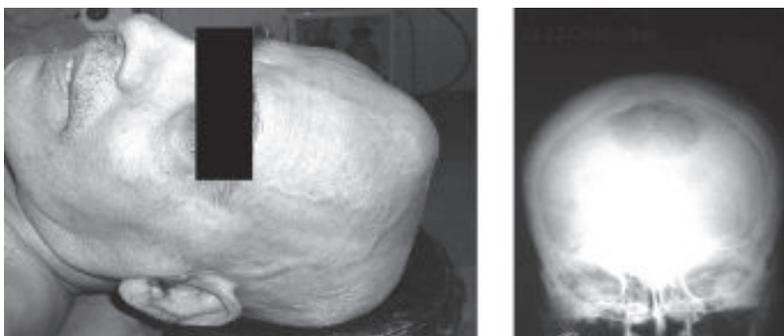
The patient with midline frontal swelling and x-ray skull shows big osteolytic lesions.
